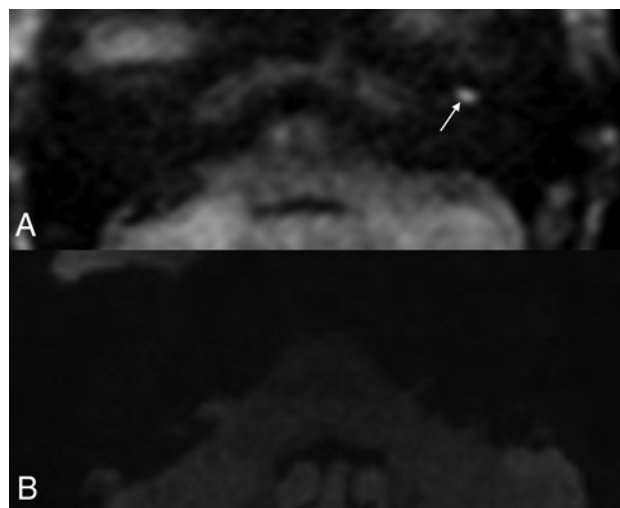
Cholesteatoma visible on HASTE but not on RESOLVE in a 69-year-old woman who had undergone a left tympanomastoidectomy approximately 15 months prior for resection of a cholesteatoma. MR imaging was performed to assess residual or recurrent disease. Axial (A) HASTE image demonstrates a well-demarcated 0.6-cm focus of restricted diffusion in the left anterior mesotympanum (*arrow*). No abnormal signal was seen on corresponding RESOLVE image (B).
